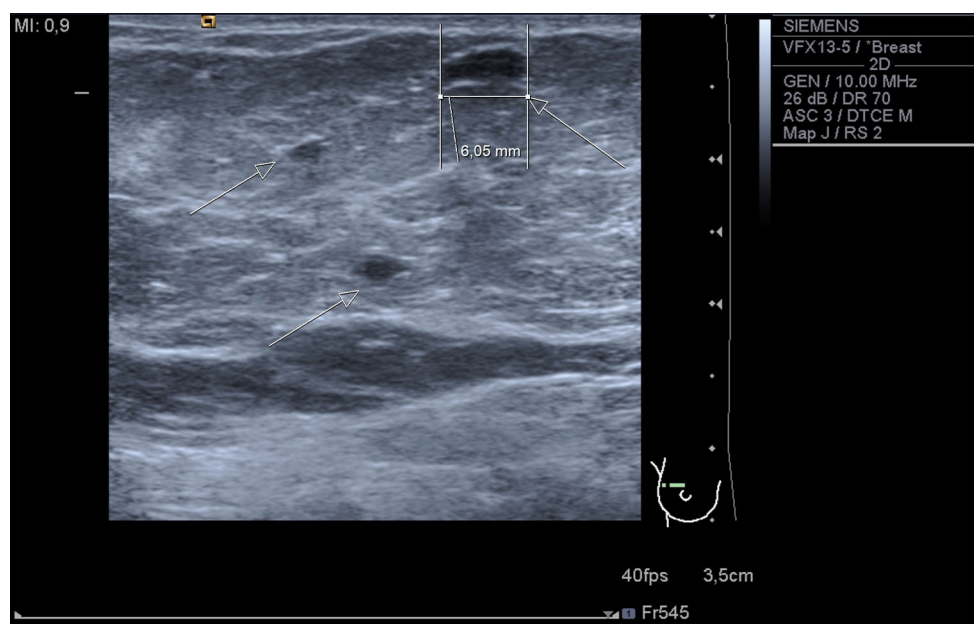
Ultrasound image after AFT, arrows indicate oil cysts
